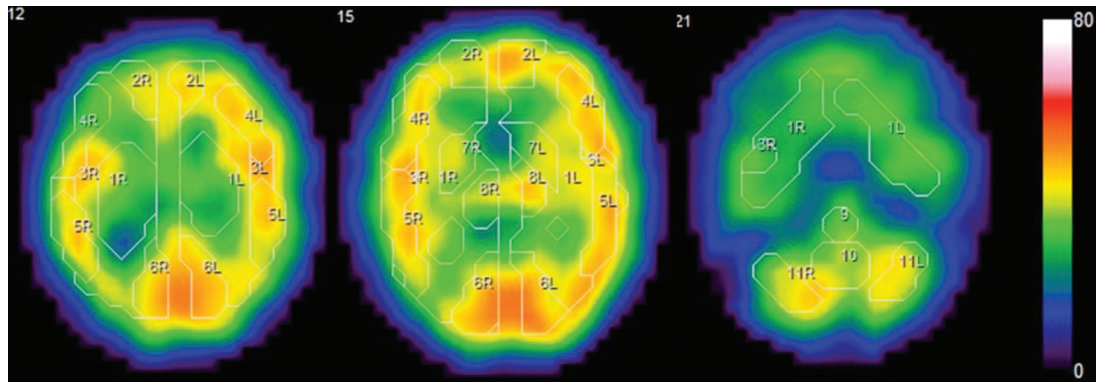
Finding of the SPECT after intracranial stenting. No laterality was observed on N-isopropyl-p-[¹²⁵I] iodoamphetamine SPECT 20 days after the operation. SPECT: single-photon emission computed tomography.
